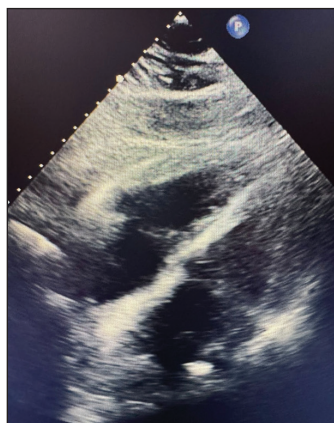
Echocardiogram of dilated right ventricle.
